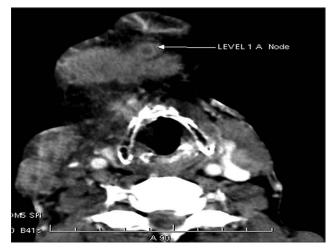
Computed tomography scan depicting submental lymph node showing central hypodensity and peripheral rim enhancement
